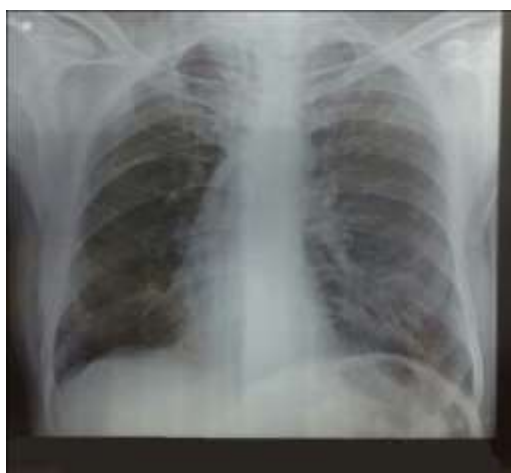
X-ray Chest (repeated) showed a congested alveolar-interstitial pattern on the left side with comparatively hyper-lucent right side lung
